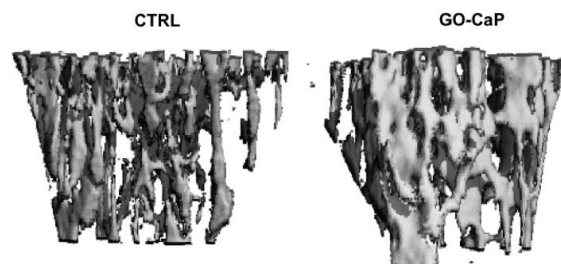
In vivo bone formation. Microcomputed tomography (μ CT) image of untreated tibia (left, CTRL) and after one month of maGO-CaP treatment (right, GO-CaP).
